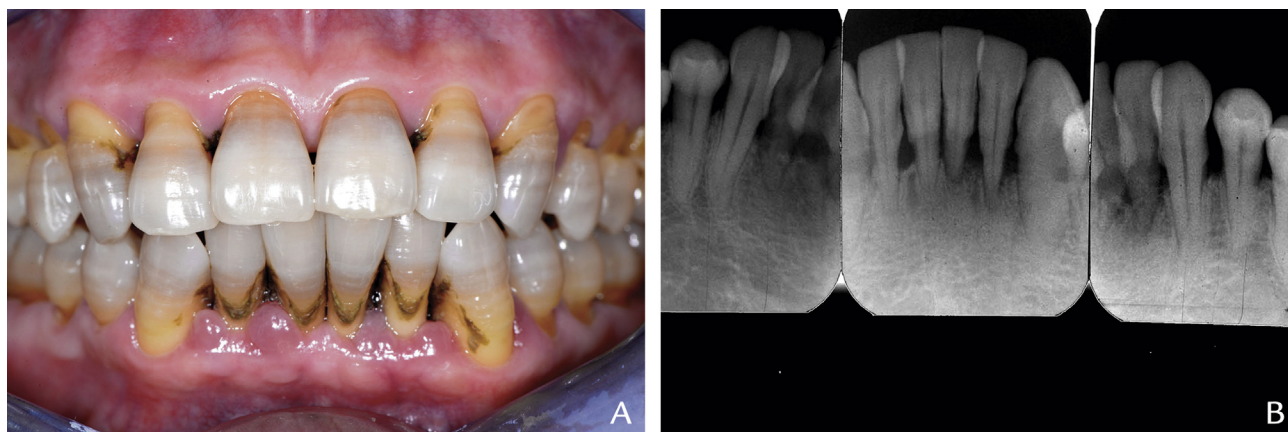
Mandibular anterior teeth before periodontal initial therapy. A, Intraoral photograph. B, Periapical radiographs.
